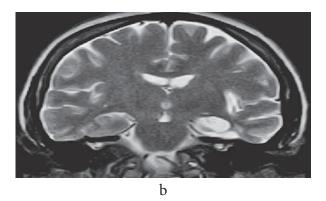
Brain MRI: T2 weighted coronal sections show extensive gliotic lesions of the left temporal lobe (a) and gliotic lesions in the region of the left hippocampus (b).
